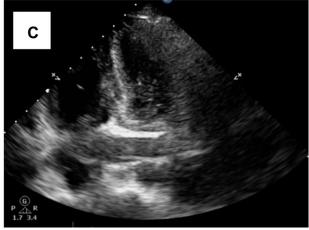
Echocardiography examination shows: (A) Coronary sinus enlargement due to the blood flow from PLSVC to right atrium (RA); (B) PLAX view shows that there is an enlargement of the coronary sinus (CS) adjacent to the descendant aorta (DA); and (C) Bubble test injected through the left cubital vein shows air bubbles filling the right atrium through the coronary sinus.
